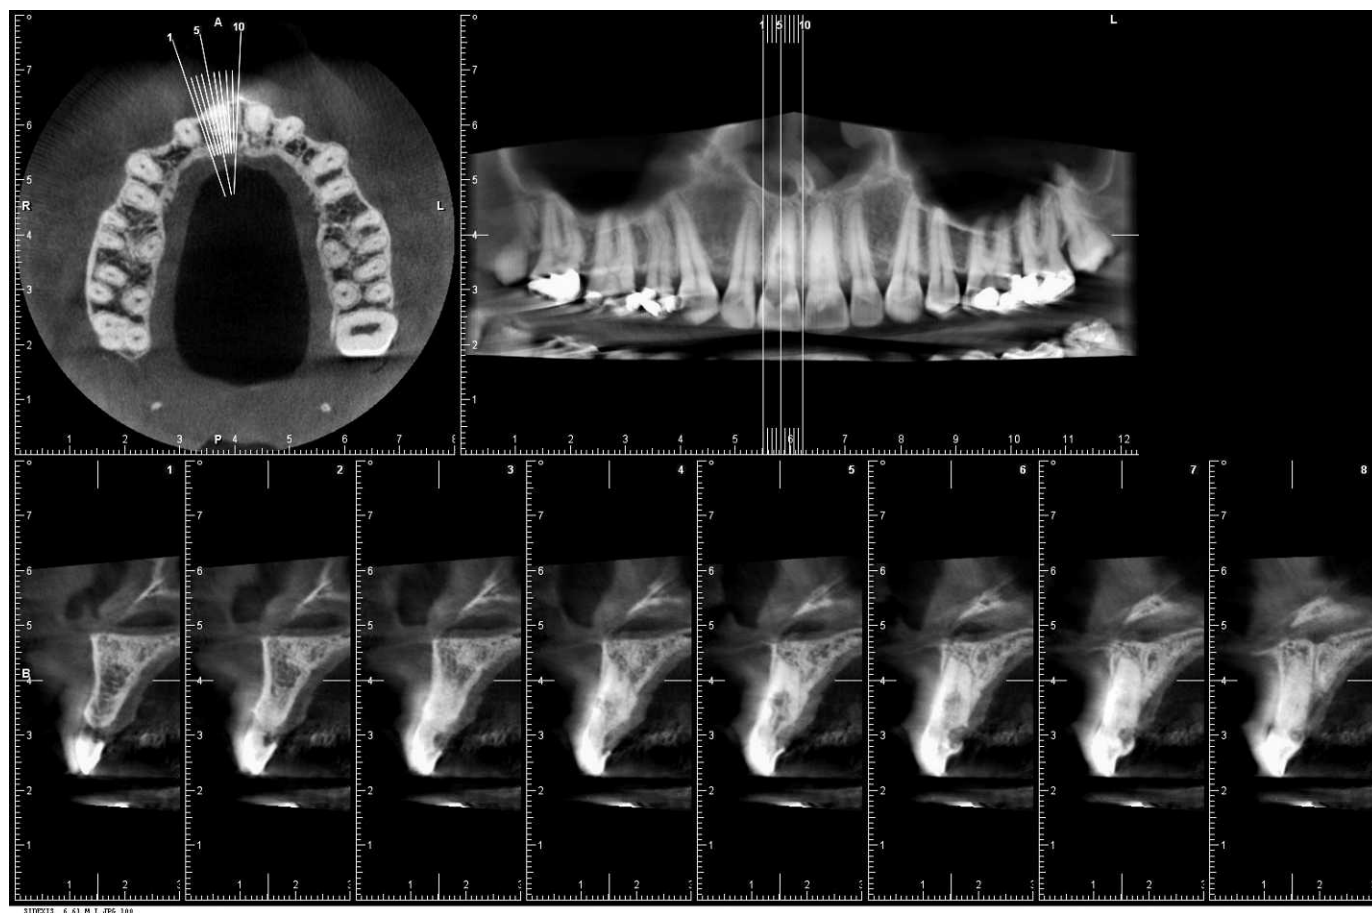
Cone-beam computed tomography after 11½ years. Note the two components of the resorptive process especially in the sixth sagittal section: a destructive part in the cervical-peripheral region and an underlying reparative part (bone formation) extending to the apical-central region.
